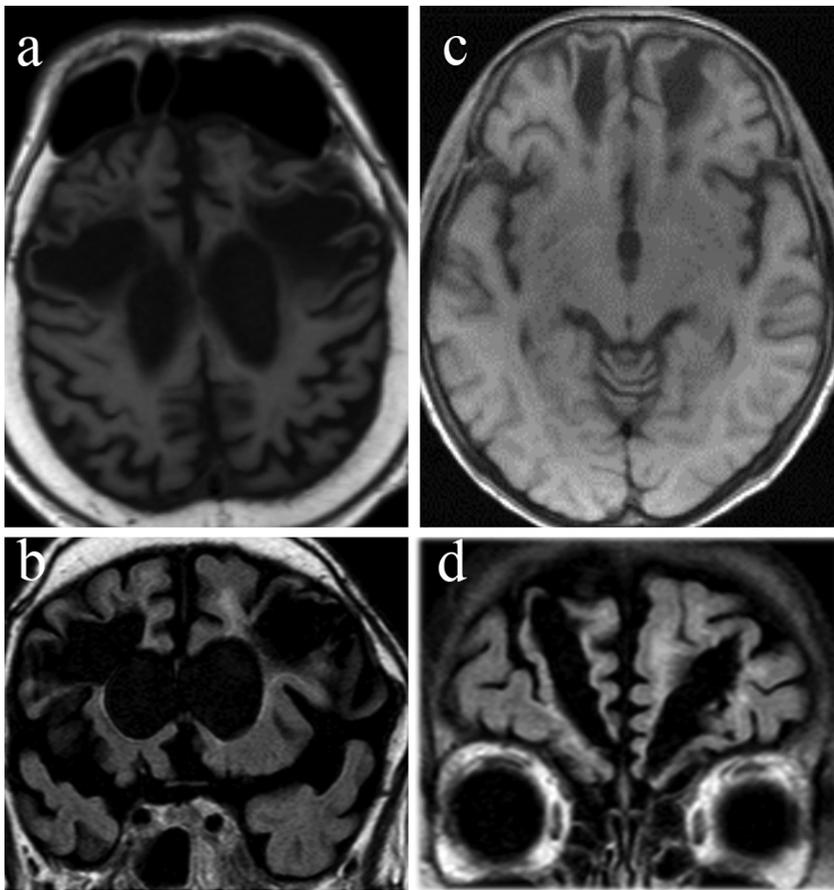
Imaging of the leucotomized schizophrenia patients. T1-weighted magnetic resonance images (MRI) of case 1 at age 76 (a, b) and case 2 at age 71 (c, d). MRI revealed cystic lesions around the anterior horn of the lateral ventricles as low intensity signals and enlarged anterior horn of the lateral ventricles. Atrophy is present in the corpus callosum.
